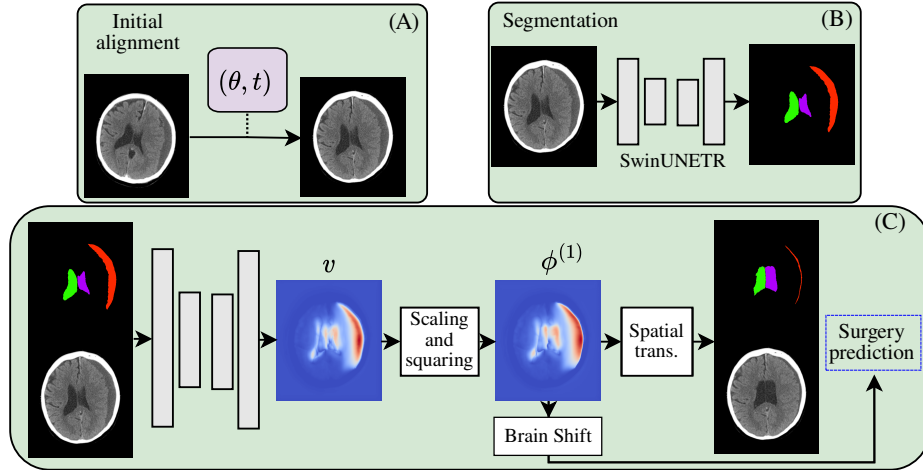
Overview of our process. Images are aligned to a sagittal plane (A) and automatically segmented (B). The CT scan and segmentations are used as input to a deep diffeomorphic registration model (C). Deformation fields provided by this model are used to distinguish between patients requiring surgery by various biomarkers.
